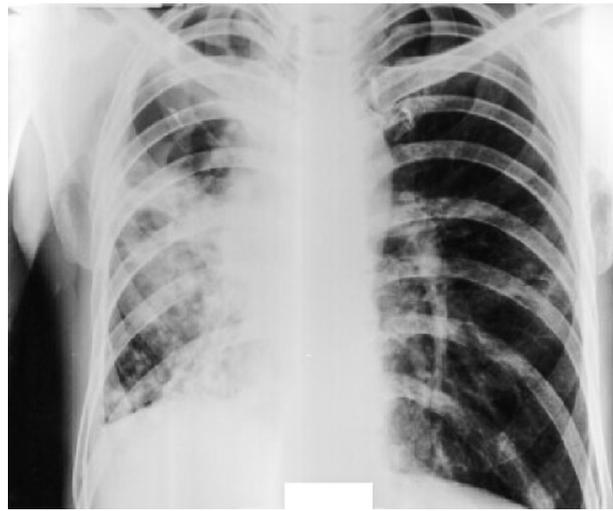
Chest X-ray after one month of inpatient treatment
